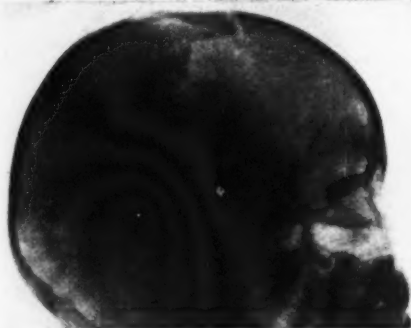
Roentgenogram of skull, May 16, 1930 (Compare the shape of the hiatus with the photograph of the fragment).
